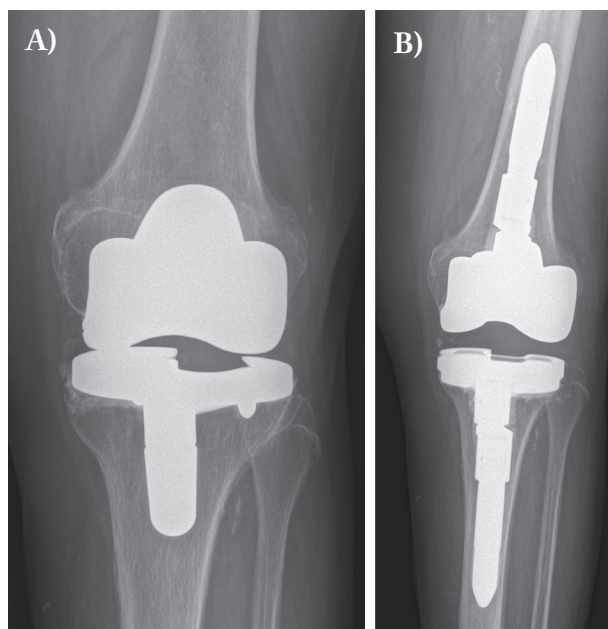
A) X-rays show TKA with tibial component malalignment; B) X-rays after revision implant
